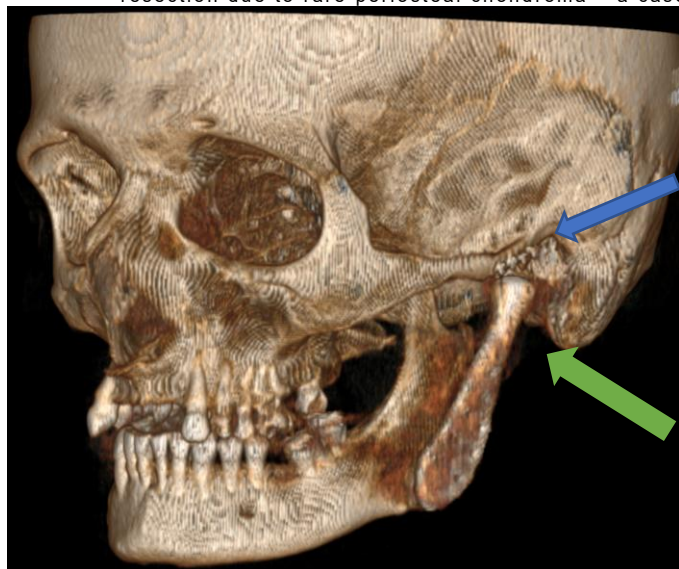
Post-surgical computed tomography. 3D reconstruction presenting correct placement of the implant (marked by a green arrow) and four dedicated screws (marked by a blue arrow) fixing the TMJ fossa component made of UHMW-PE (radiolucent material – not visible on radiographs) (RadiAnt DICOM Viewer 2025.2).
